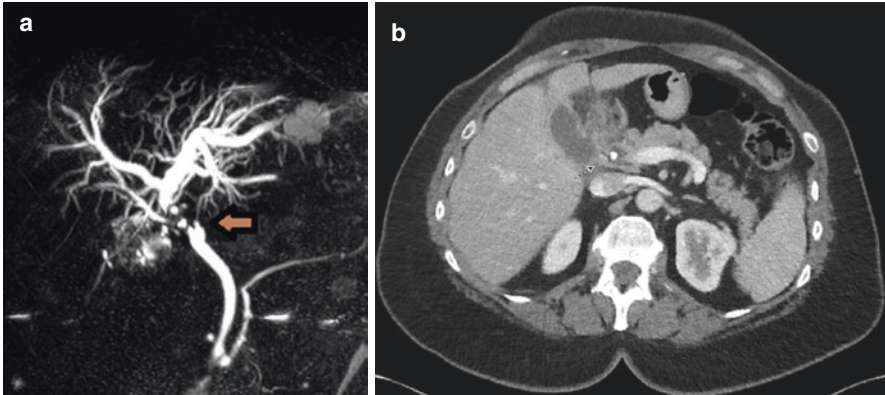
Case 3: Stone disease. (a) MRI/MRCP: dilatation of the perihilar and intrahepatic bile ducts with obstructing cystic duct stone suspicious for Mirizzi syndrome (b) CT scan: thickening of the hepatic duct suspicious for cholangiocarcinoma
